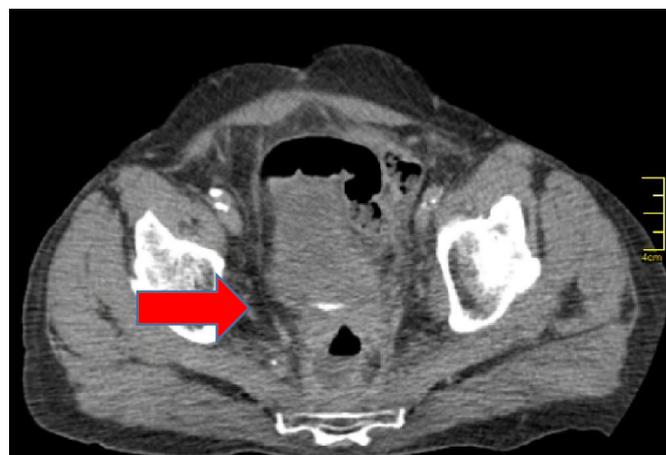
Contrast-enhanced abdominal CT scan (arterial phase; arrow pointing towards the tumor, invading the urinary bladder) – coronal view
